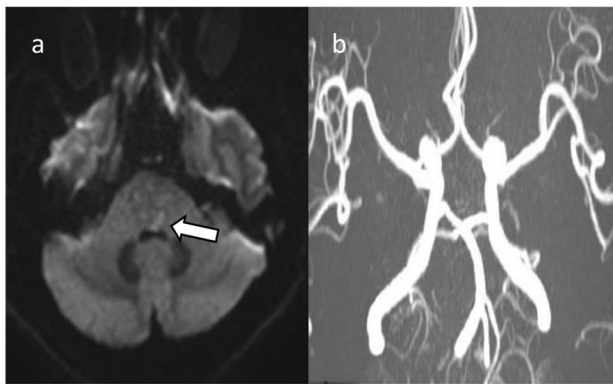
Cranial magnetic resonance image 2 day after disease onset revealed restricted diffusion (arrow) in the pons on the DWI sequence (a) without significant arterial stenosis on cranial MRA (b)
